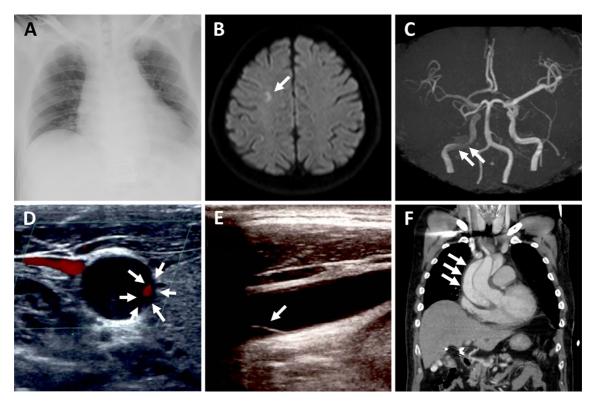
(A) A supine chest X-ray (anteroposterior view) showed no abnormal findings, including no enlargement of the mediastinum. (B) Brain magnetic resonance imaging revealed a right frontoparietal ischemic lesion (arrow). (C) Brain magnetic resonance angiography demonstrated a low signal in the right internal carotid artery (arrows). (D) Carotid duplex ultrasonography demonstrated 95% occlusion of the right common carotid artery with a large false lumen and small true lumen (arrows), and a dissecting intima was present in the left internal carotid artery (arrow, E). (F) Chest computed tomography revealed a Stanford type A ascending aortic dissection extending to the aortic arch (arrows).
